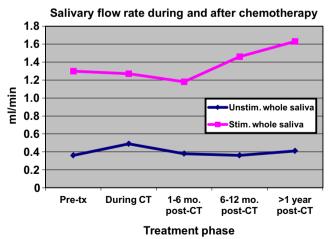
Pooled and weighted data of unstimulated and stimulated whole saliva flow changes with chemotherapy. *Tx* treatment, *CT* chemotherapy, *Mo*. months, *Unstim*. unstimulated, *Stim*. stimulated. Based on references [27, 179–184, 186, 188, 190, 192]
